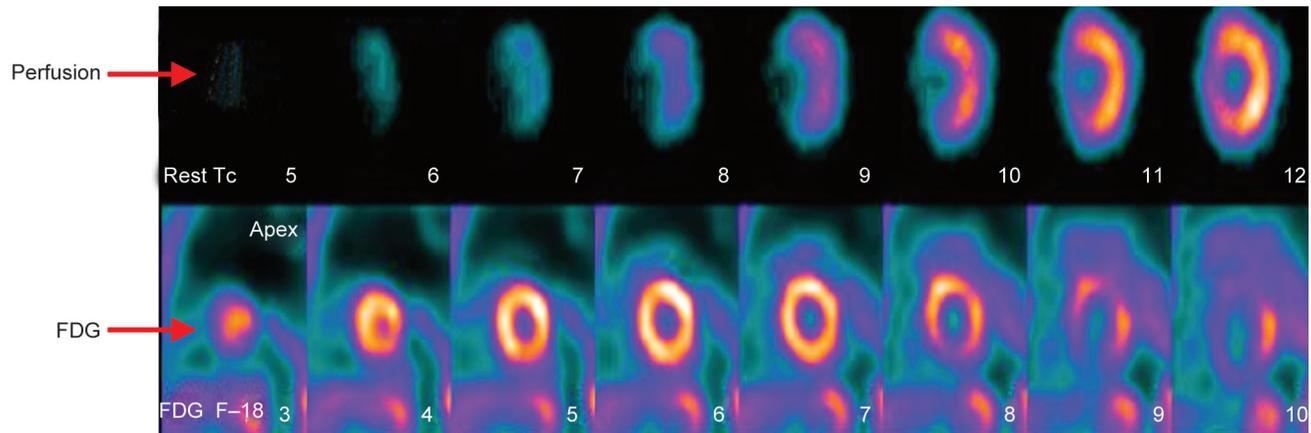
FDG PET depiction of viable myocardium in LAD territory (perfusion metabolism mismatch)
